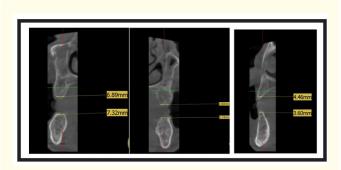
CBCT images depicting crestal bone width a. Molar Region Right and b. Left, and C. Anterior Region.
